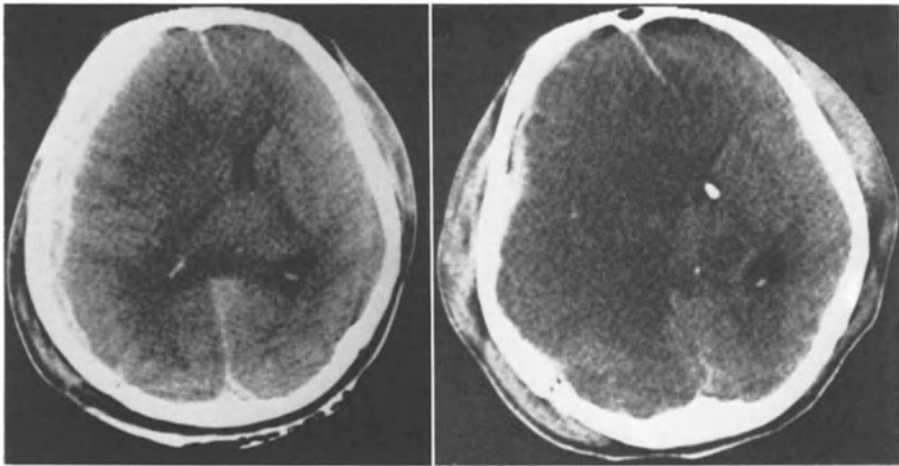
This 25 year-old man was admitted 20 minutes after suffering a traffic accident. He showed bilateral fixed dilated pupils and the GCS score was 3. There was moderate arterial hypotension and hypoxia. The admission CT scan (left) showed an acute subdural haematoma over the whole hemispheric convexity causing marked midline displacement. Despite of rapid haemodynamic stabilization and haematoma removal, the patient's condition did not improve. The postoperative control CT scan (right) showed persistent midline shift with diffuse hypodensity of the ipsilateral cerebral hemisphere; haematoma reaccumulation was visible only in one CT slice. Raised ICP could not be controlled and the patient died within two days after injury
